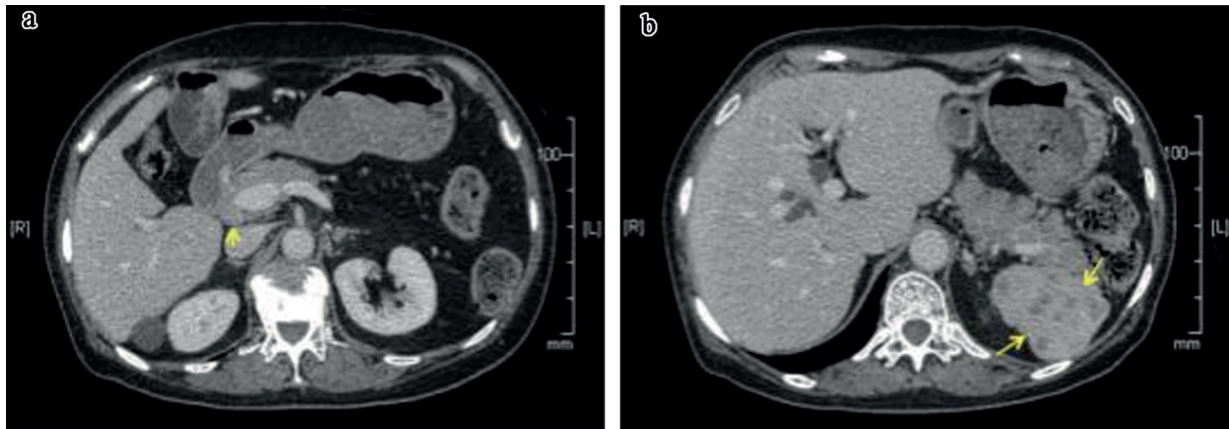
CT detection of colorectal cancer patient lymph node metastasis. Yellow arrow: metastatic lymph node.
